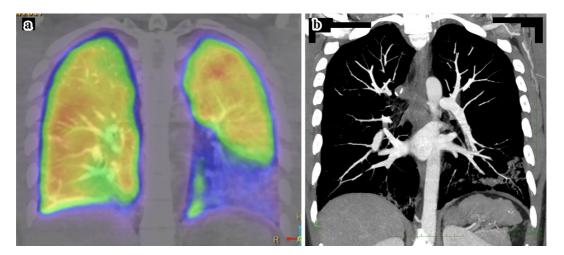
Lung perfusion scintigraphy on the sixth day of hospitalization (a) and computed tomography angiography of the pulmonary artery on the seventh day of hospitalization (b). A marked decrease in blood flow can be observed on the left lower lobe (a). No apparent embolism can be found in the pulmonary artery (b).
